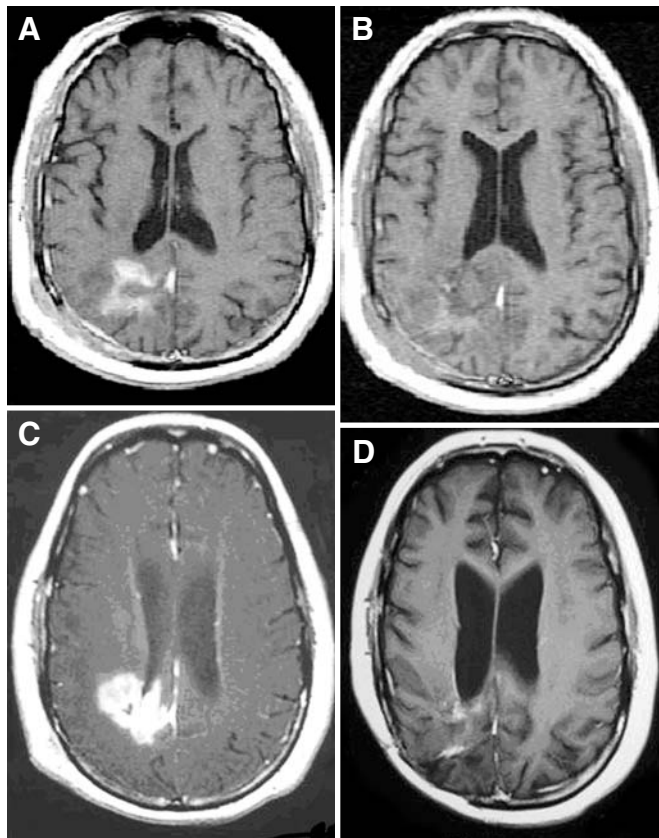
Enhanced T1-weighted MRI scans obtained from Patient 3 before (A) and after (B) MRIgFUS treatment. Note the loss of enhancement at the treated site. T1-weighted MRI scans obtained from Patient 3 showing the new enhancing lesion at the treated site 4 months after treatment (C) and several months later (D) showing spontaneous resolution of the enhancing mass.
